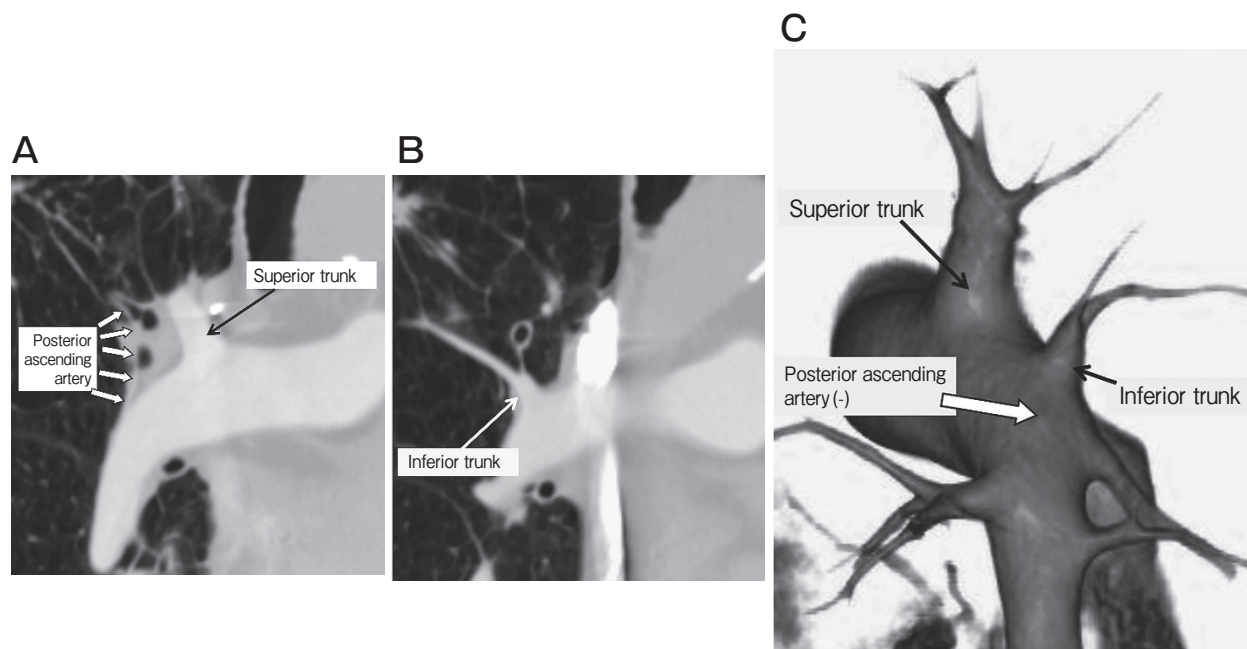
Coronal multiplanar reconstruction (MPR) and three-dimensional computed tomography pulmonary angiography (3D-CTPA) images of the right pulmonary artery. In these example MPR images (A, B), the superior trunk, inferior trunk, and ascending artery arising directly from the main pulmonary artery are detected. In the example 3D-CTPA image (C), the superior trunk and inferior trunk from the main pulmonary artery are identified but the ascending artery is not detected.
